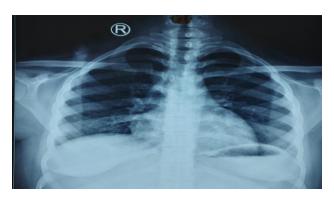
X-ray chest postero-anterior view two weeks after discharge.
